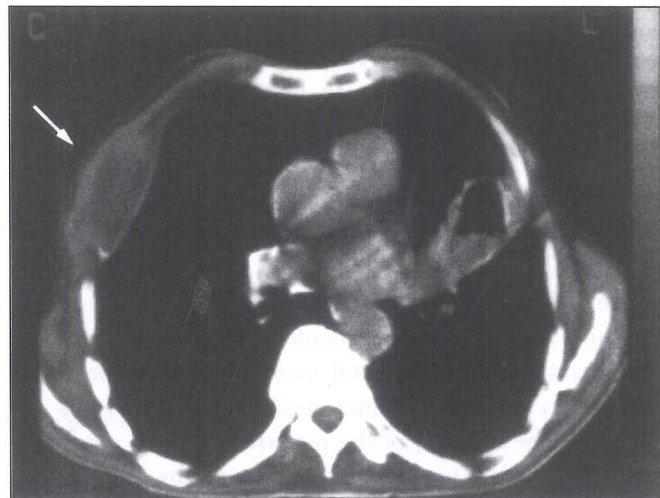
Chest CT showing the soft tissue masses in the right pectoralis major and the lingular segment.
